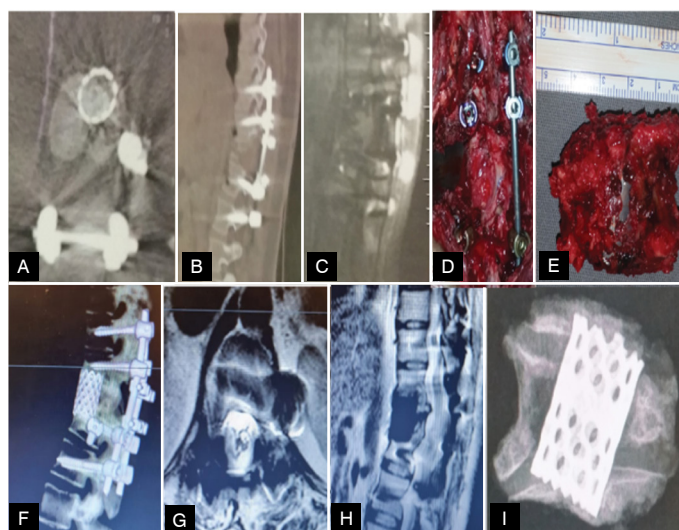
Case of a 26-year-old woman with prior emergency double-approach surgery for a pathological fracture. (A-B) CT scans (axial and sagittal) showing recurrence of the giant cell tumor. (C) MRI reveals a large tumor mass. (D-E) Posterior *en bloc* resection of T12. (F) Postoperative CT reconstruction. (G-H) MRI (axial and sagittal) demonstrating effective spinal cord decompression with no signs of recurrence. (I) Intraoperative radiograph showing the T12 recurrence, anterior cage, and adjacent endplates of T11 and L1.
